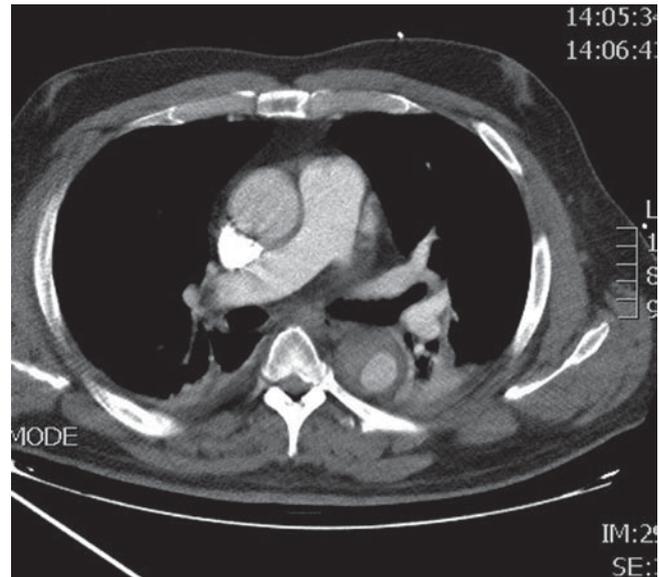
Classical or Class 1 B-type acute aortic dissection. The axial view discloses the dual lumen into the descending thoracic aorta. There are stick artefacts into the ascending aorta caused by iodine contrast filling the superior cava vein. The tear was in the distal aortic arch (not shown). The false lumen unveils less attenuation than true ones secondary to a lesser degree of flow and contrast filling. If the tear is not clearly visible, differentiation with intra-mural haematoma could be challenging and another imaging technique (i.e. transoesophageal echocardiography) needed
